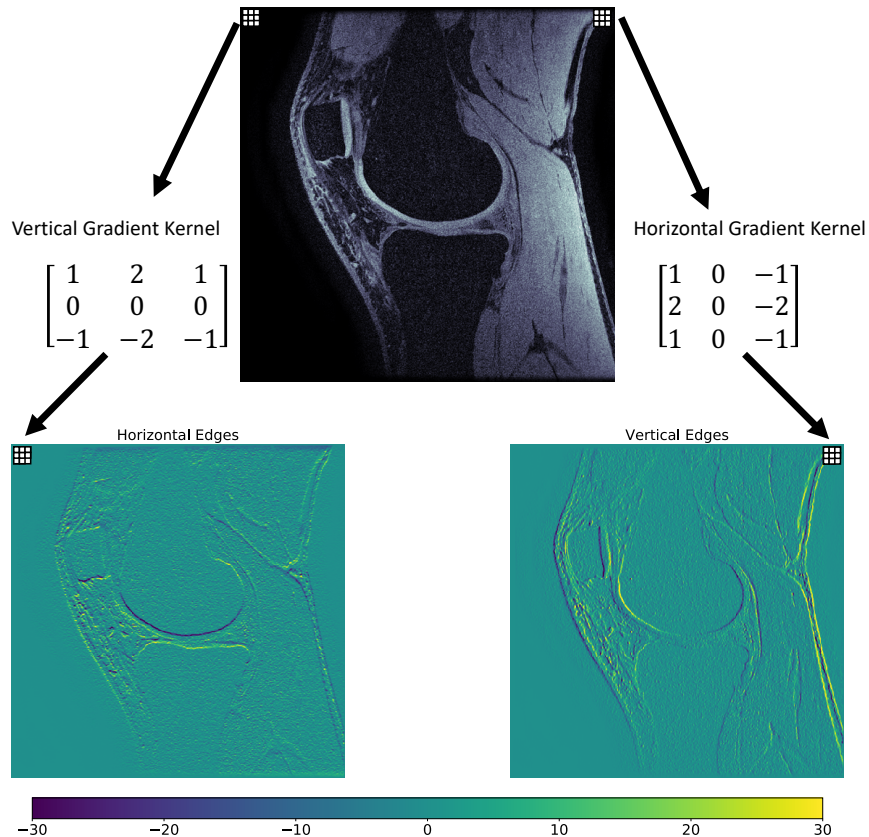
Sobel filter, an example of a convolutional filter. The Sobel filter calculates the gradient of the image in the horizontal or vertical directions. These gradients identify lines that run perpendicular to them because we expect there to be a gradient in the image when we cross an edge or boundary between two regions or colors in an image. If there is no gradient, then the output is zero (no edges). This can be seen by the mostly homogenously 0 (teal) coloring in the consistently dark regions of bone or background in the original image. To achieve this, the kernel (vertical gradient or horizontal gradient kernel shown in the figure) slides over the entire image. As it slides, the kernel is multiplied elementwise by the pixels that lay underneath it and then these products are summed together; the sum is placed at the center of the kernel in the output image. Examples for applying the vertical gradient kernel to get the horizontal edges and the horizontal gradient kernel to get the vertical edges are shown in the figure for a sagittal slice of a knee MRI. The absolute magnitude of the output images identifies how “prominent” the edge is, or how large the gradient change is. The sign of each pixel
